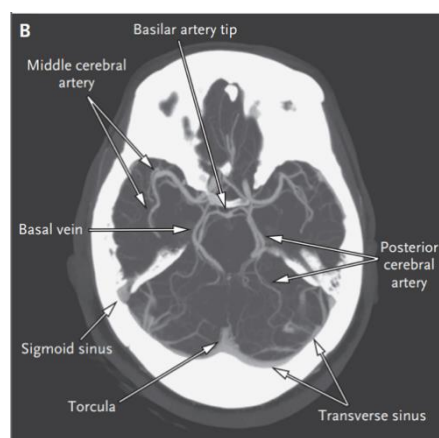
CT angiography of the head
